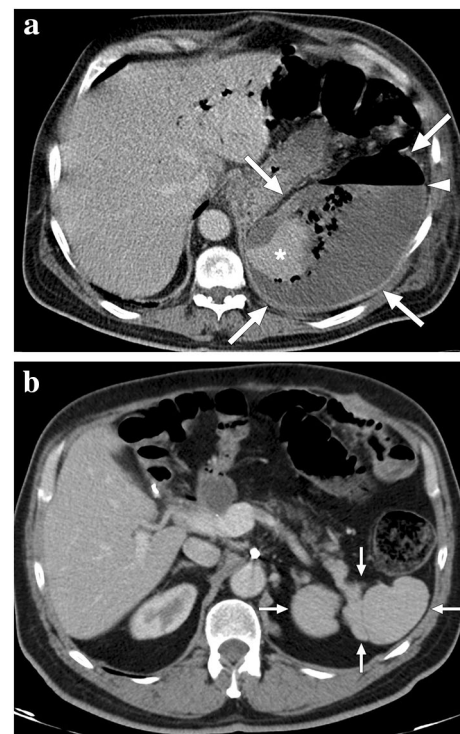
A 60-year-old male patient with known pancreatic cancer. A splenic artery pseudoaneurysm and a large hematoma were detected in the surgical bed 10 days after the Whipple procedure, and endovascular embolization of the pseudoaneurysm was performed (not shown). The patient presented to ER with left upper quadrant pain, high fever, and chills 9 days after the embolization procedure. a Axial plane postcontrast abdominal CT showed a large splenic abscess with air–fluid level (arrowhead), which almost completely replaced the splenic parenchyma (arrows). Viable parenchyma could only be seen in a small area within the lower pole of the spleen (asterisk). Percutaneous abscess drainage revealed purulent content, and culture grew *Klebsiella pneumoniae*. The patient was placed on IV antibiotics after catheter placement and was discharged uneventfully within 3 weeks. b Follow-up abdominal CT 2 years after the initial presentation showed complete regression of splenic abscess and multilobulated residual spleen parenchymae (arrows)
